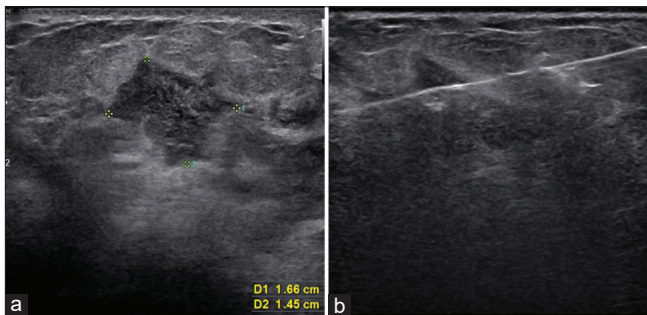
The initial transverse ultrasonography shows an irregular shape hypoechoic nodule with an indistinct margin in the right breast at the 9-o'clock position. (a) and ultrasonography-guided biopsy was performed with 14-gauge needle (b)
